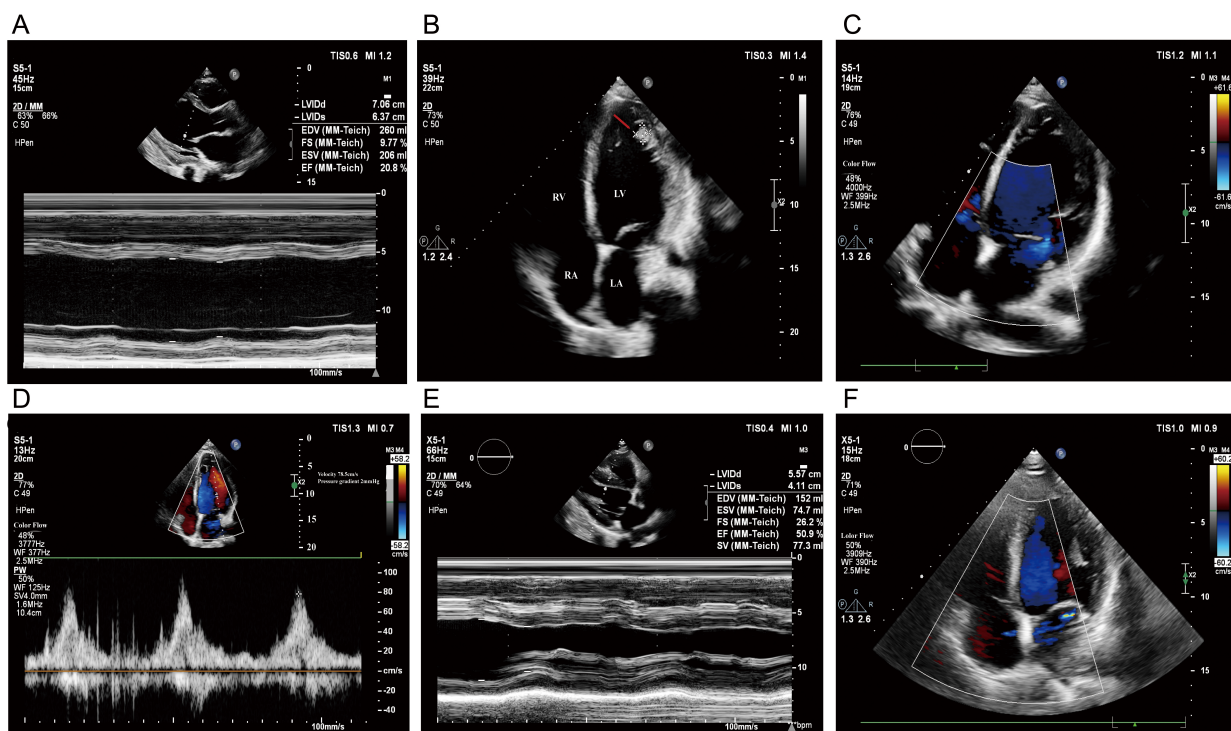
Serial echocardiographic images during follow-up. (A) Day 3: M-mode measurement of the left ventricle demonstrated reduced systolic function. (B) Day 3: Apical four-chamber view showing diffuse left ventricular enlargement and intraventricular thrombus formation. The thrombus is seen adjacent to the left ventricular wall (red arrow). (C) Day 17: Apical four-chamber view showing resolution of the left ventricular thrombus. (D) Day 30 follow-up: Apical four-chamber view showing mild reduction in left ventricular systolic and diastolic function. (E) Day 90 follow-up: M-mode measurement showing normalization of left ventricular systolic function. (F) Apical four-chamber view demonstrating restoration of normal chamber size. RA: Right atrium; RV: right ventricle; LA: left atrium; LV: left ventricle.
